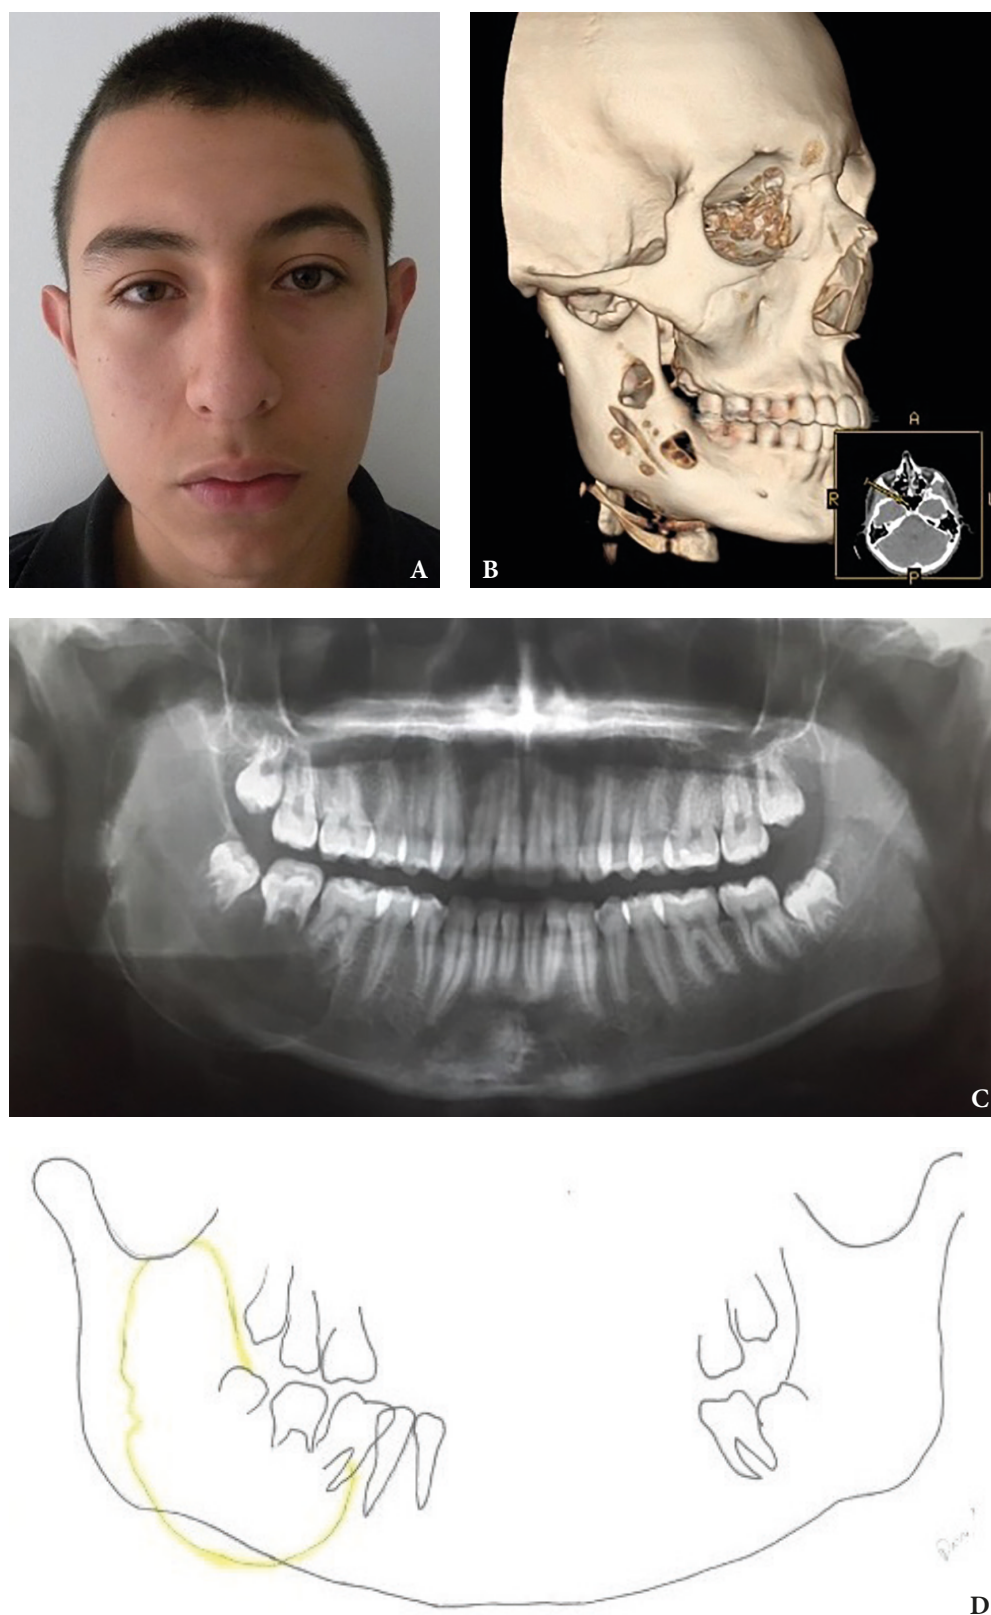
Case 2. A: Mild swelling in the right mandibular body, with tenderness. B: 3-dimensional computed tomography (CT) scan shows a lesion in the right mandibular body with perforation of the vestibular cortex. C: Panoramic X-ray shows a lesion in the right body and ramus related to first, second and third molar with apparent compromise of the inferior alveolar nerve. D: Lesion size scheme (yellow) for resection.
